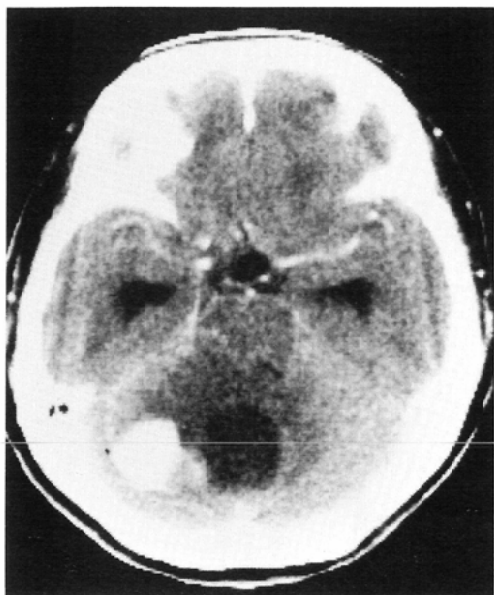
Postcontrast CT scan. A large tumor with nodular enhancement and a cystic component is demonstrated in the right side of the cerebellum.
